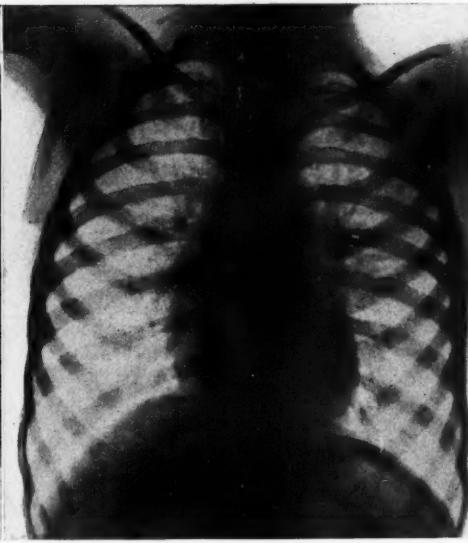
B. Chest radiograph of case shown in Figure 2 A.
